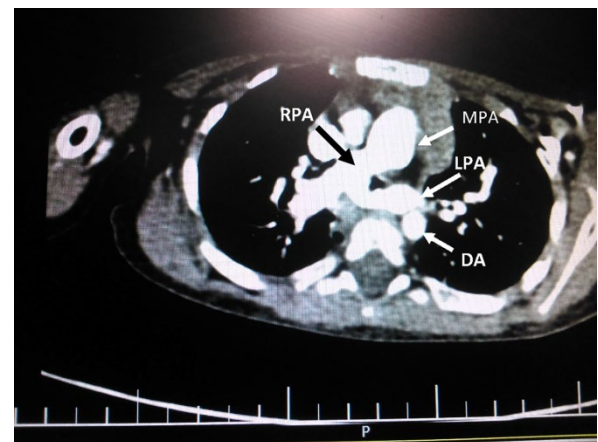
CT angiography showing abnormal arising of LPA from RPA.
